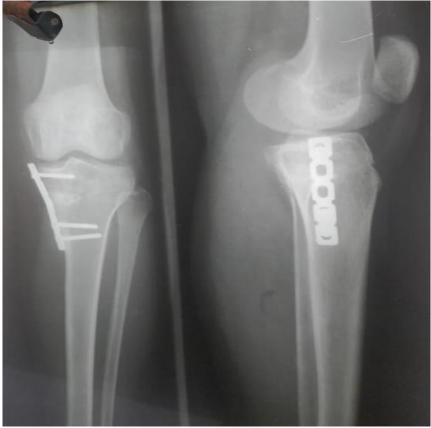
Post op Xray of Tibial osteotomy with plating with Allograft
